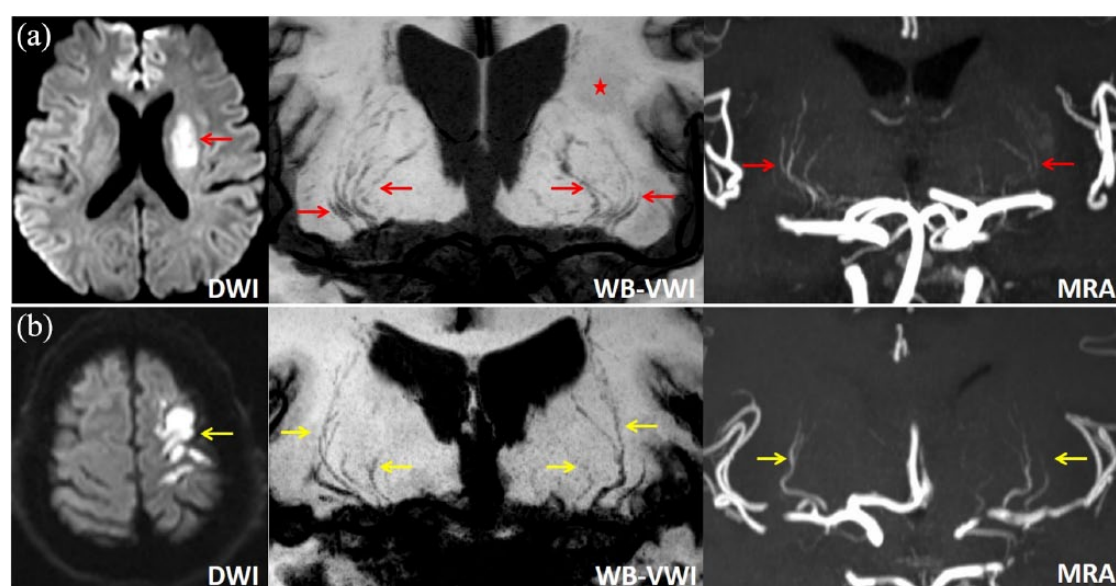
Representative cases of DPI (a) and non-DPI (b). (a) DWI with a high signal intensity lesion (red arrow) in the left basal ganglia, WB-VWI and MRA showing pruning of the left LSA branches compared with the right normal side (red arrows), and WB-VWI revealing the left infarction with slightly low signal intensity (asterisk). (b) DWI with multiple high signal intensity lesions (yellow arrow) in the left cortico-subcortical area, WB-VWI and MRA revealing almost symmetrical LSA branches of the ipsilateral left and the contralateral right hemispheres (yellow arrows).
